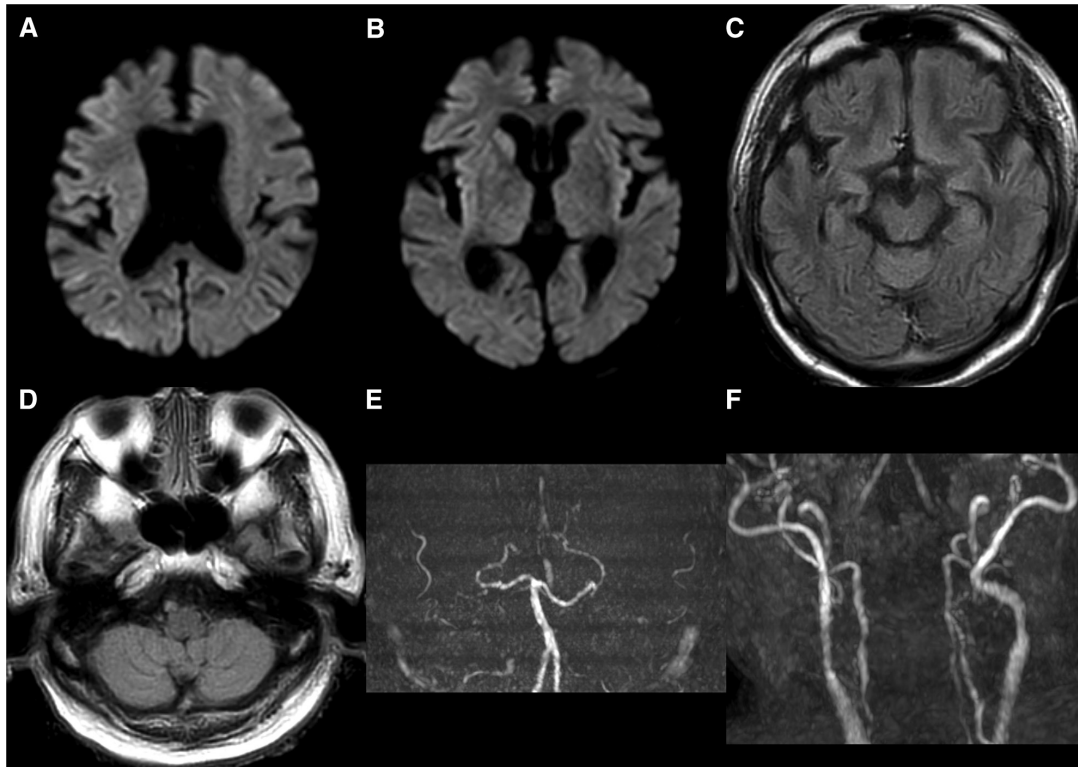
Brain MRI and MRA about 90 minutes after onset. (A and B) Diffusion-weighted images showing slightly hyperintense signals in both cerebral hemispheres (ASPECTS+W: R 6, L 8). (C and D) FLAIR images showing hyperintense vessel signs in bilateral middle and anterior cerebral arteries and also bilateral petrous ICAs. (E and F) Brain and cervical MRA showing bilateral ICA occlusions. ASPECTS+W: Alberta stroke program early CT score + white matter; ICA: internal carotid artery; L: left; R: right
